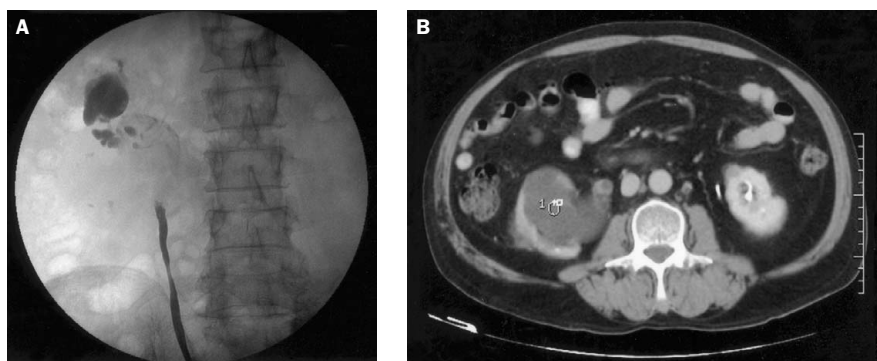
(A) Retrograde pyelography reveals obstruction over the right upper ureter and filling defect over the dilated proximal urinary tract. (B) Abdominal computed tomography shows partial obstruction over the upper ureter, with measurable mean value of 10.33 HU over the central portion of hydronephrotic content that is compatible with mucous substance.
